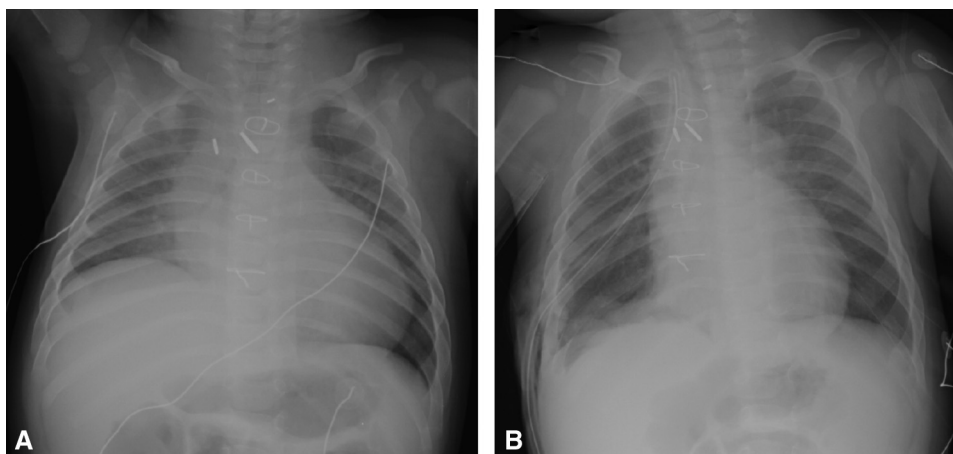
Plain radiograph of 1 patient after Glenn procedure with right hemidiaphragm elevation (A) and after right hemidiaphragm plication (B).
